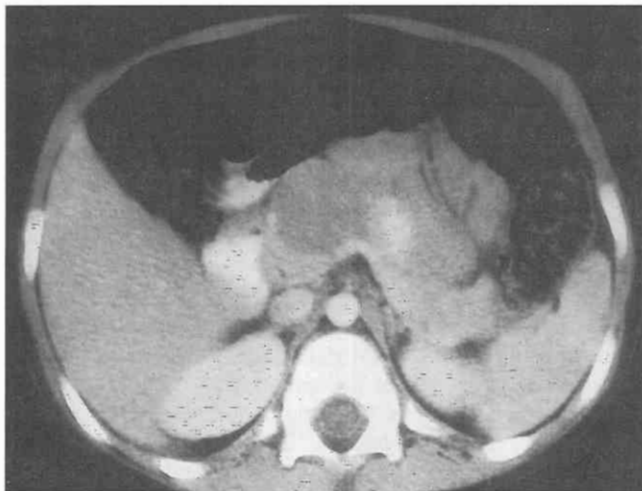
Pancreatic lymphoma. CT scan through the pancreas in a patient with non-Hodgkin's lymphoma demonstrates a rounded, low-attenuation, solid mass in the head of the pancreas.
